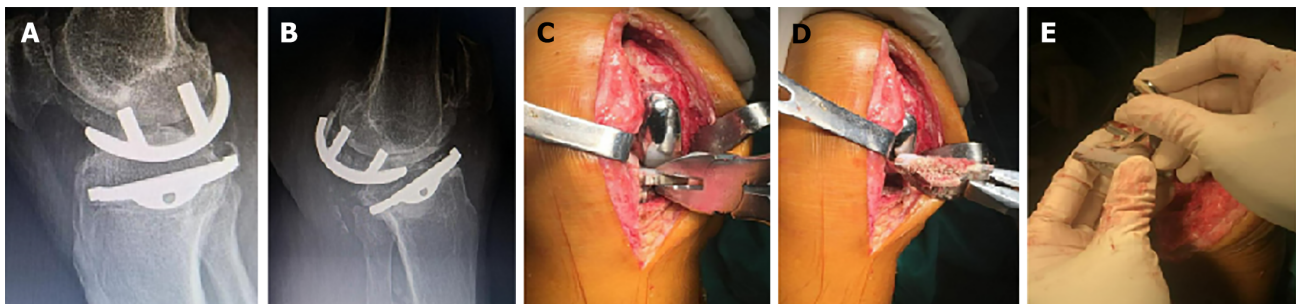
Treatment process (right knee) for Patient 6. A: Anteroposterior X-ray before revision; B: Lateral X-ray before revision; C: The tibial prosthesis was loose; D: The tibial prosthesis was easily removed during revision; E: The femoral prosthesis was removed and modified for total knee arthroplasty.
